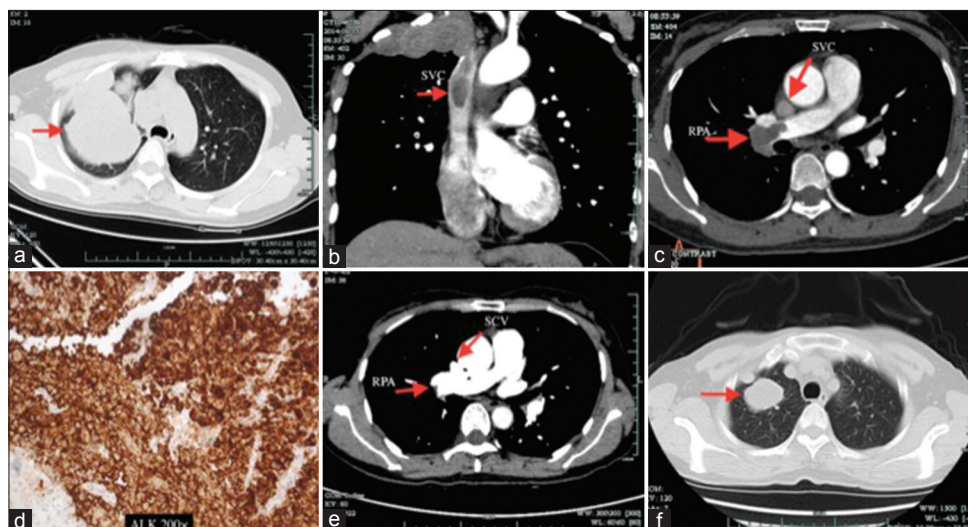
Chest CT revealed soft-tissue shadows in the right upper lung (arrow; a). CTA showed the thrombi in SVC (arrow; b). CTA showed the thrombi in the RPA (left arrow) and SVC (right arrow; c). ALK was positive with ICH/VANTANA ($\times 200$; d). CTA showed the thrombi in the pulmonary artery (left arrow) and superior vena cava (right arrow) disappeared after 1 year (e). Chest CT showed the lesion reduced after therapy for 3 years (f). CT: Computer tomography; CTA: CT angiography; RPA: Right pulmonary artery; SVC: Superior vena cava; ALK: Anaplastic lymphoma kinase.
